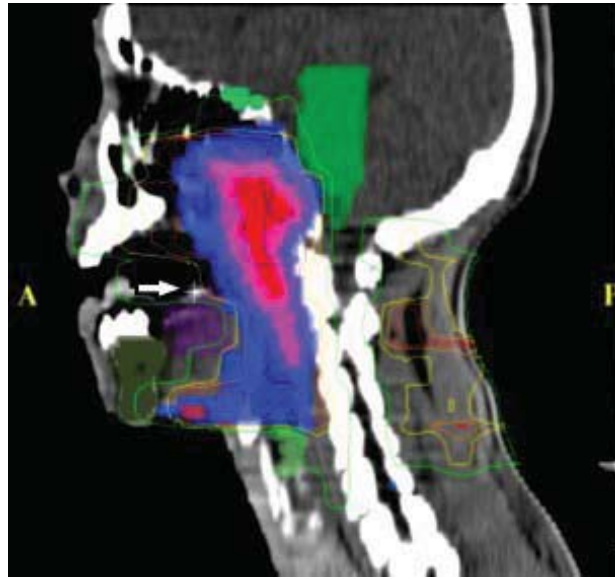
Example of Corvus IMRT treatment plan. The MOSkinTM detector can be identified on the patient CT images as shown by the white arrow.
